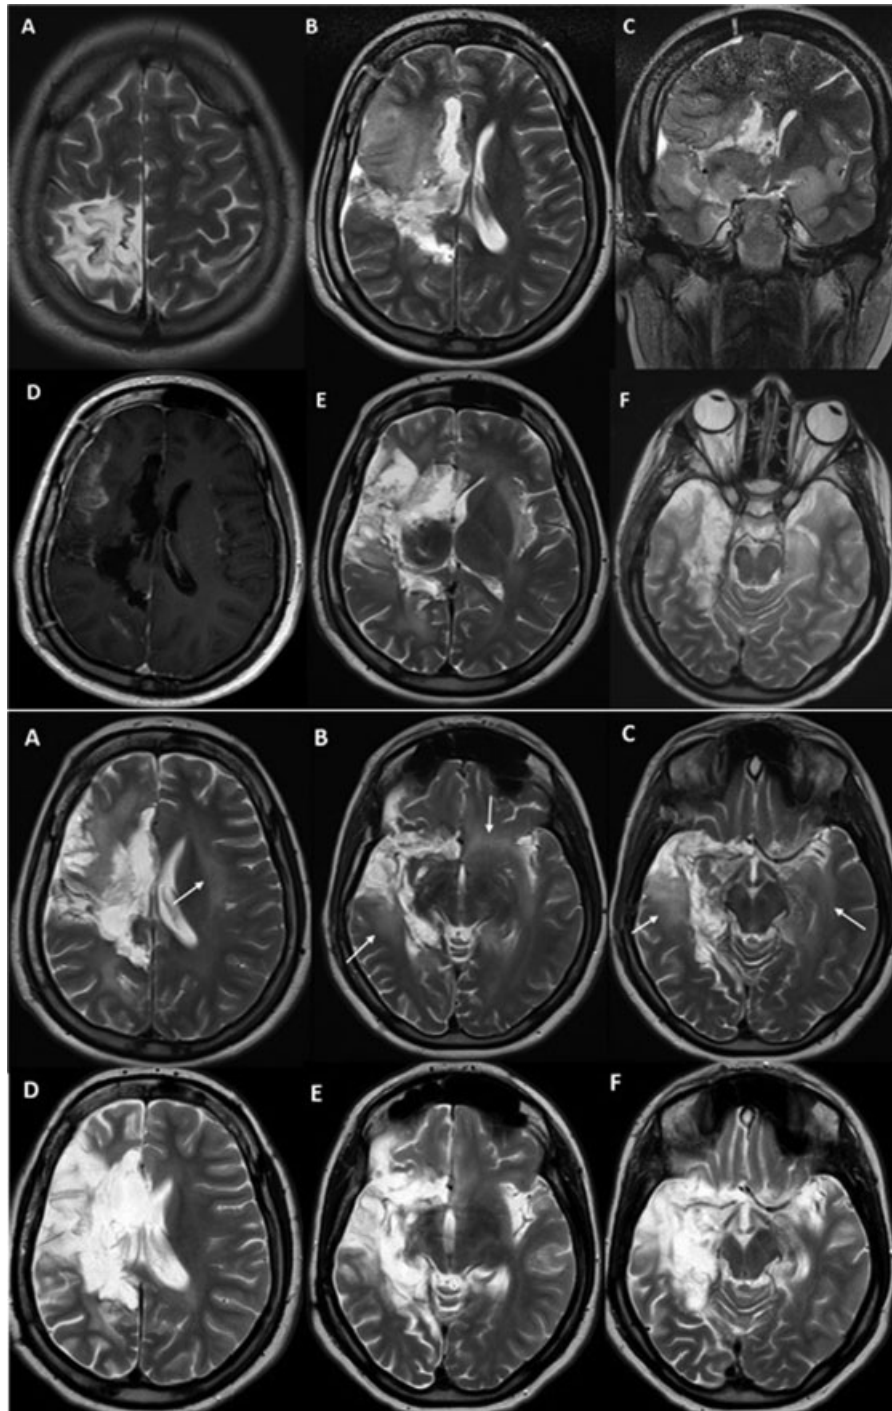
(Upper part) (A–F) Preoperative axial T2W image shows right perirolandic cortical and subcortical hyperintense chronic lesion (A). Five days after right-side hemispherotomy surgery. Axial (B) and coronal (C) T2W images show bilateral insular and medial temporal abnormal T2 hyperintensity and swelling. Postcontrast T1W image reveals gyral enhancement of the lesions (D). Thirty days after onset of neurological symptoms show decrease in signal intensity in lesions on T2W images (E, F). (Lower part) (A–F). At postoperative day 62, axial T2W images show new hyperintense lesions on medial temporal lobes, left inferior frontal region, and centrum semiovale (A–C, arrows). At postoperative day 92, axial T2W images demonstrate marked cystic encephalomalacia and volume loss in affected areas (D–F). T1W, T1-weighted; T2W, T2-weighted.
